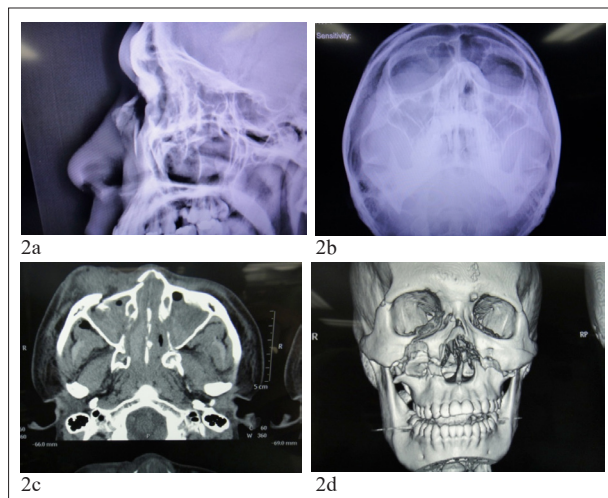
Investigations for nasal bone fracture; lateral nasal bone (2a), skull water's view (2b), CT- brain bone window (2c), and CT facial bone (2d).
